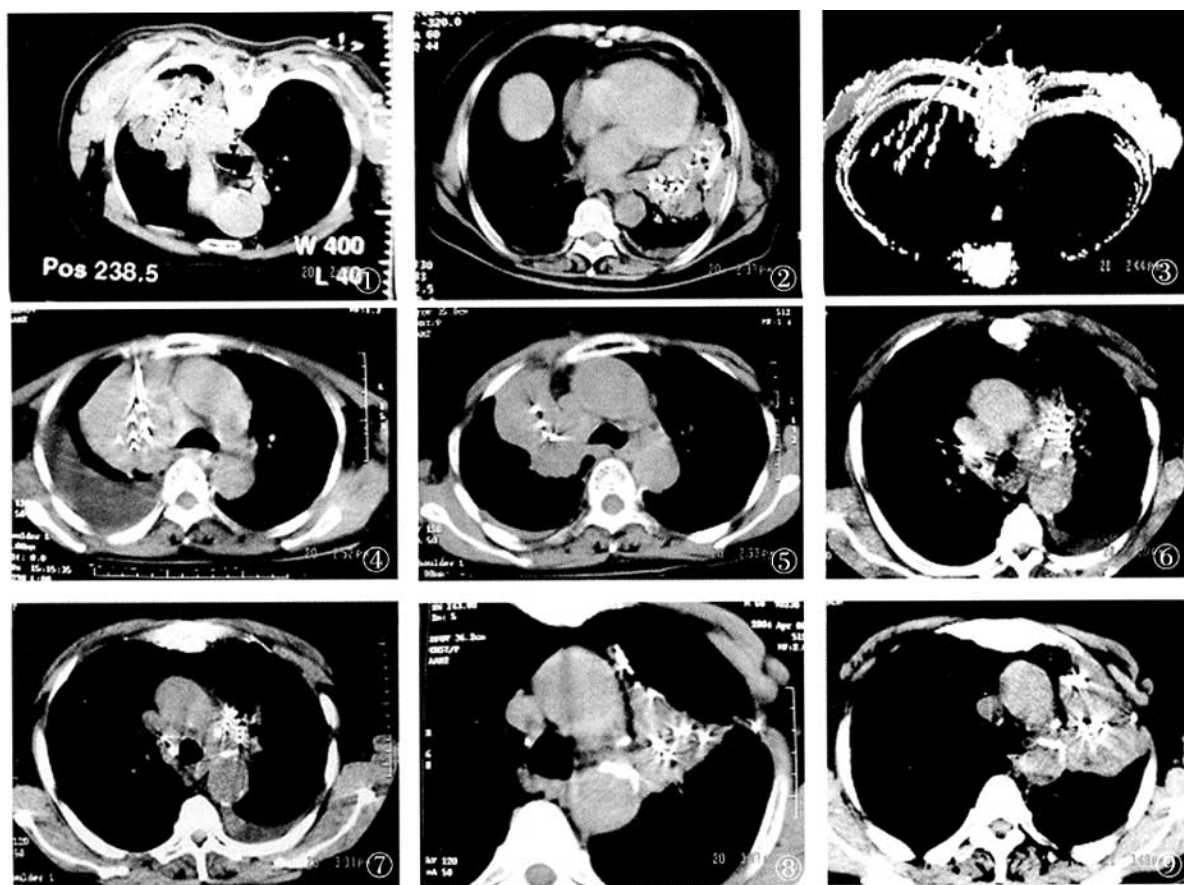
The CT guided implanting needle was first placed on the target, 1 to 4 grains of the microparticles were released by the gun in series, with 1.0 to 1.5 cm space between the particles. CT scanning was conducted immediately.
